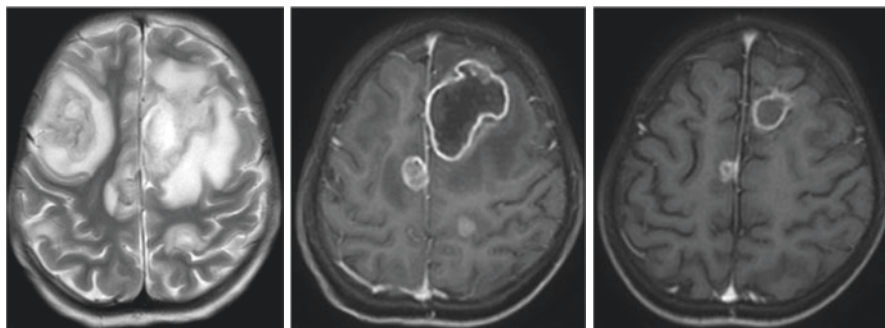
Child on chemotherapy of acute myeloid leukaemia developed seizures, high-grade fever. MRI shows enhancing lesions. Her serum galactomannan was high suggestive of aspergillus abscess. She responded to Intravenous voriconazole (extreme right image)
